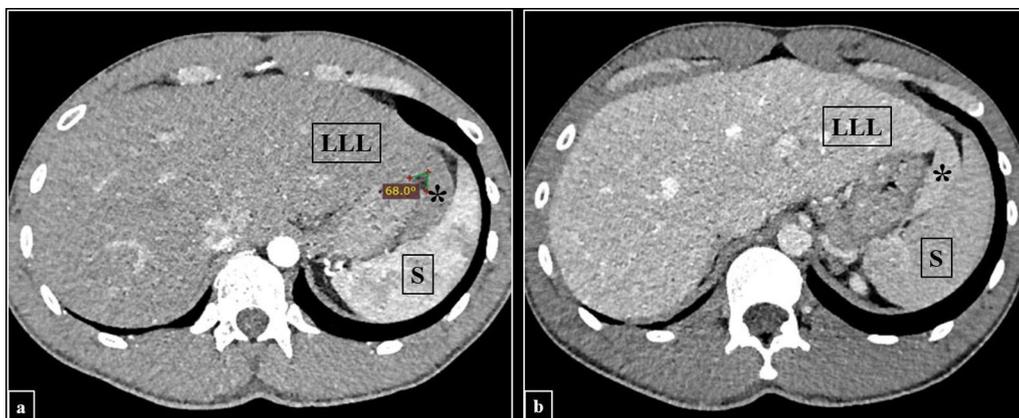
CT scan of the abdomen and pelvis. Axial CT image in the arterial (a) and portal (b) scanning phase demonstrate extension of the lateral part of the left liver lobe (LLL) across the midline. Following an acute angulation (a), the left liver lobe parenchyma is seen to assume a crescent shape (asterisk), lying juxtaposed to the spleen (S) medially to its visceral surface
